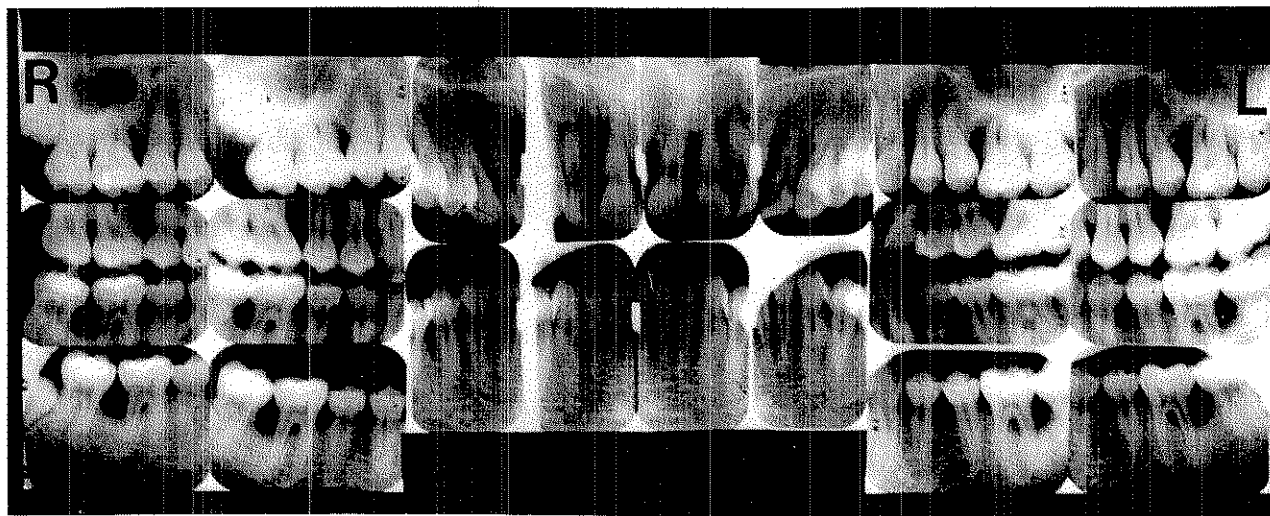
Case #1, radiographs at initial visit, November 1976. R = right; L = left.
